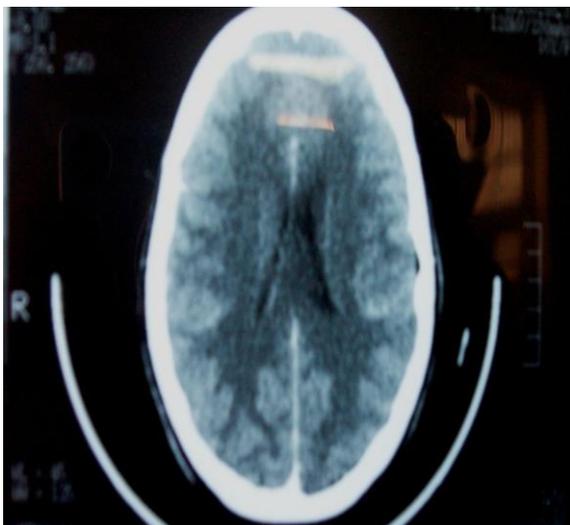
CT scan revealing mild cortical atrophy and focal calvarial thickening.
